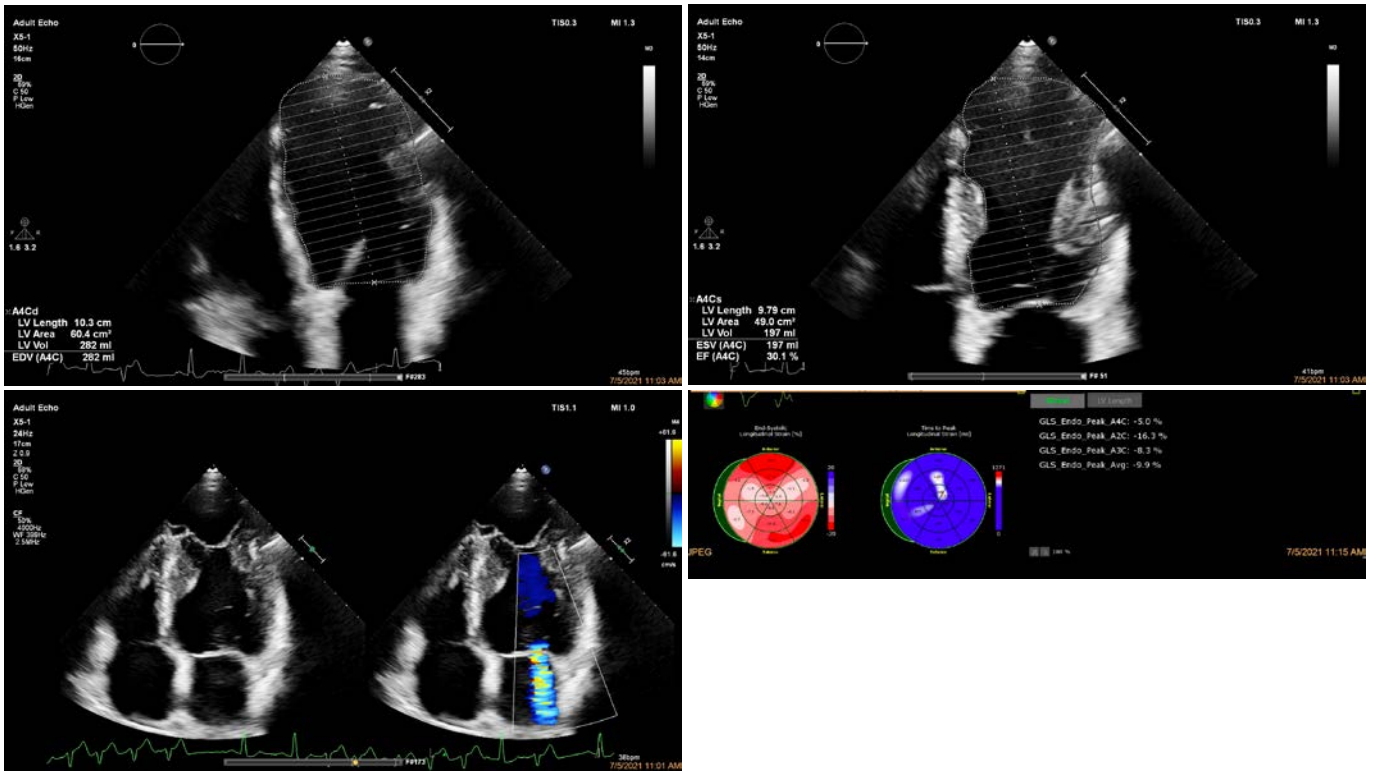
Transthoracic echocardiography: anteroapical left ventricular aneurysm, ischemic mitral regurgitation, assessment of left ventricular ejection fraction with Simpson's biplane method and of left ventricular global longitudinal strain with speckle-tracking echocardiography
